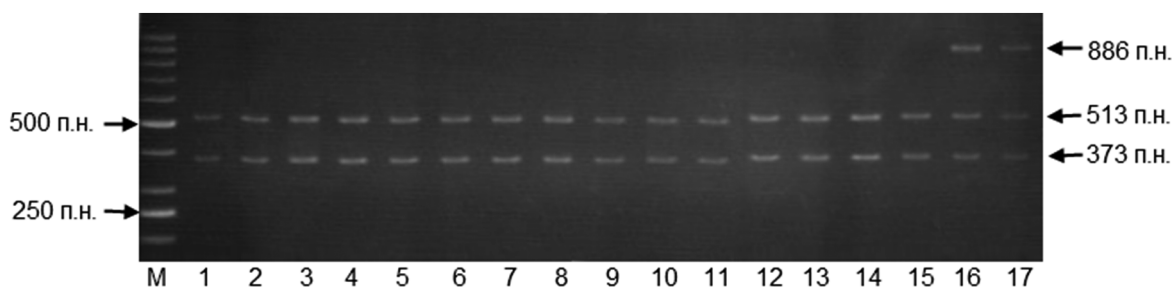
Electrophoregram of restricted fragments distribution of gene *MATN3* (C908T). Samples 1-15 correspond to CC-genotype; samples 16-17 – CT genotype; M – molecular mass marker.
